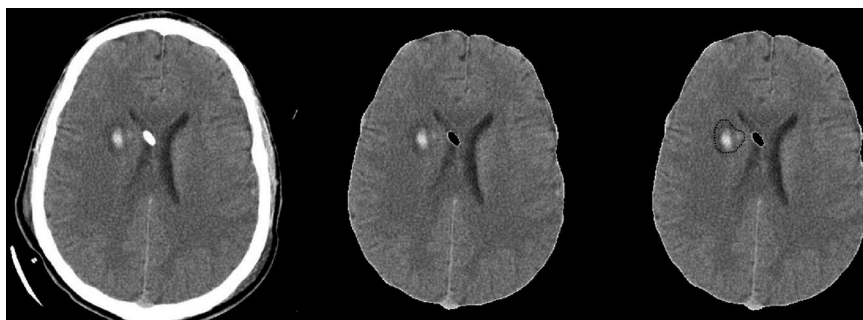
Original computed tomography scan image (left panel). Automatic isolation of the intracranial compartment by the software (middle panel). Isolation of the contused and noncontused tissue (right panel). Note that the intraventricular derivation catheter is excluded from intracranial compartment.
